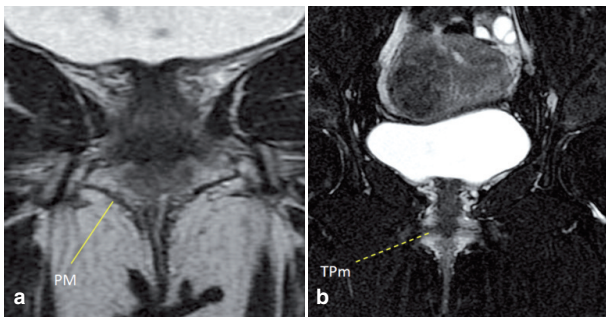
(a) The perineal membrane is depicted on coronal T2-weighted TSE images as a triangular shaped structure of intermediate signal intensity (*continuous line*), uniting the ischiopubic rami of one side to the other. Figure (b) Corresponding STIR image (b) showing at best the superficial transverse muscle of perineus as a hypointense horizontal structure (*dotted line*). PM= perineal membrane; TPm =transversus perinei muscle.
